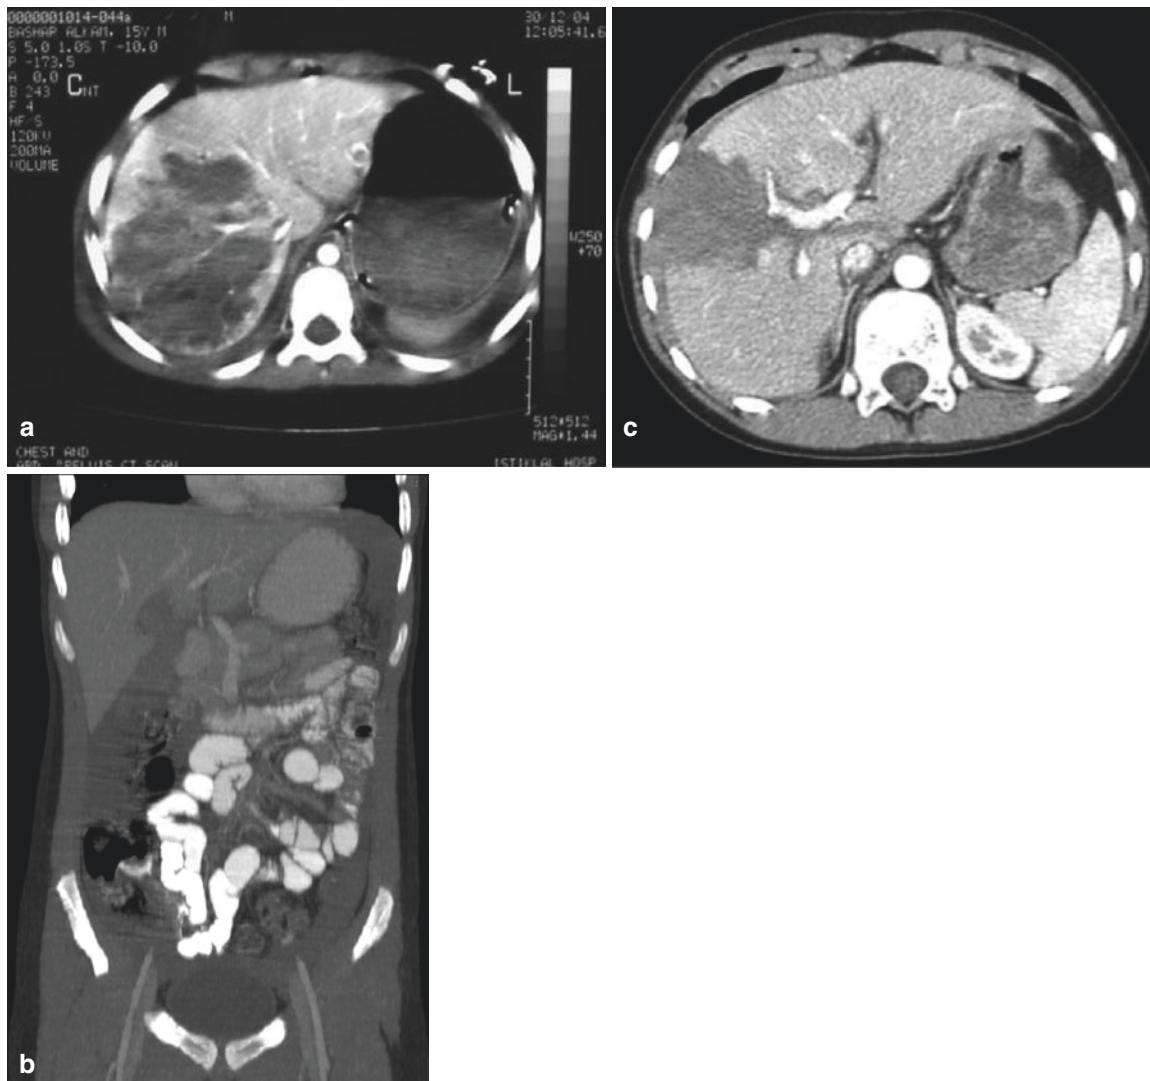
(a) Major trauma. CT scan showing major disruption of the liver with a large haematoma in the right lobe of the liver and capsular tear. (b) Trauma with liver injury and hemoperitoneum. (c) CT scan showing a fracture of the liver with capsular tear and subcapsular haematoma
